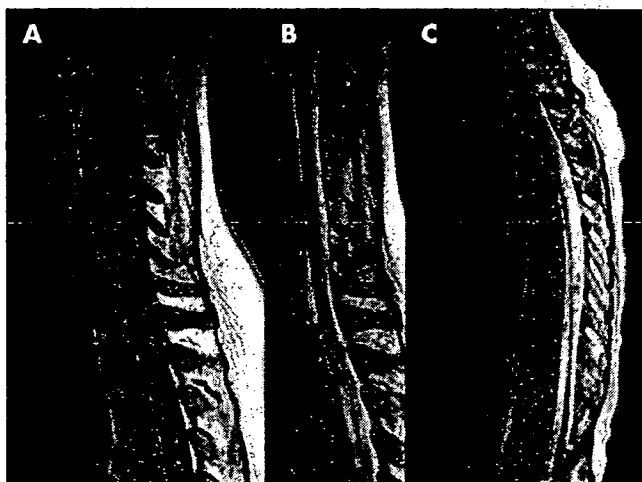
MRI findings of patients with long spinal cord lesions-multiple sclerosis (LCL-MS). The patient shows discontinuous enhanced lesions from C1 to Th5 (A) and discontinuous T2 high intensity lesions in the cervical segment and T2 high intensity lesions from Th1 to Th5 (long T2 lesion) (B). Another patient shows segmental spinal cord atrophy from C7 to Th11 (C).
